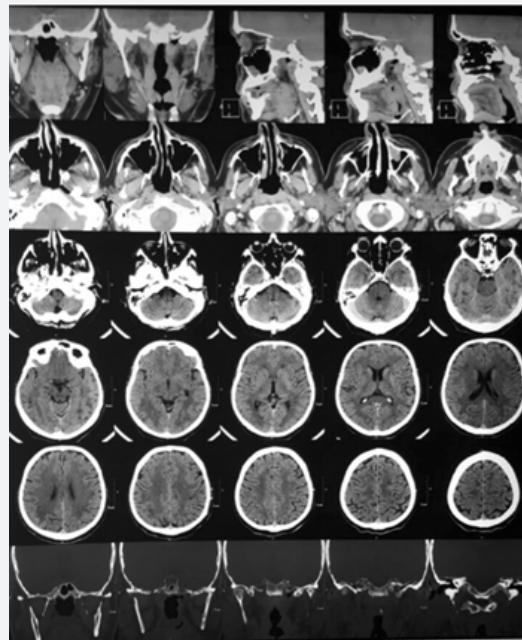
CT images of skull base after treatment.
